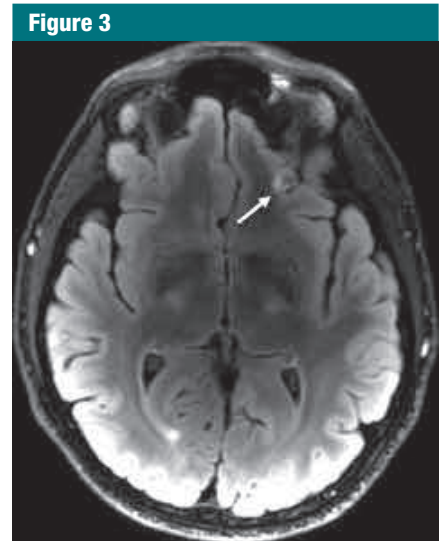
Axial T2 FLAIR image with small focus of encephalomalacia and gliosis in the inferior left frontal lobe (arrow) in a 26-year-old man with blast-related mild TBI.
